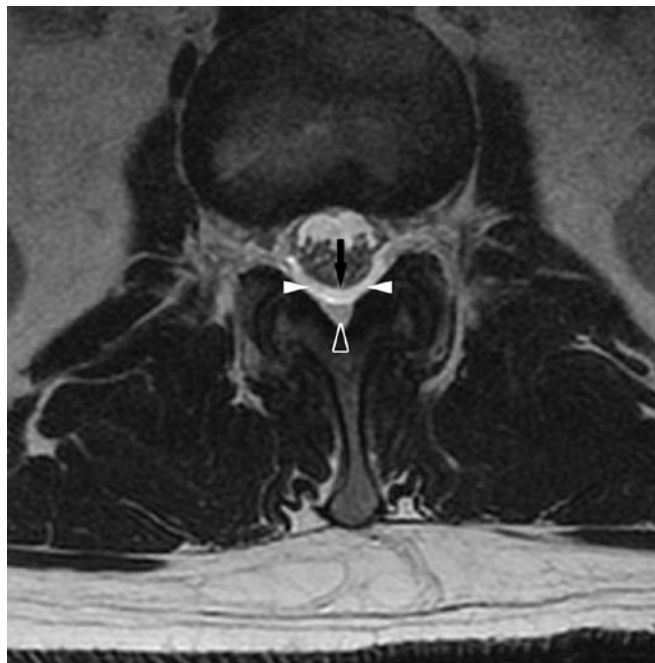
Axial T2-weighted image from lumbar spine MRI demonstrates an abnormal epidural fluid collection (white arrowheads) dorsal to the dura (black arrow) at L2-3. The fluid is slightly more hyperintense than the adjacent fat in the dorsal epidural space (open arrowhead). Because of the presence of this prominent epidural fluid collection, the decision was made to perform the epidural blood patch under CT-guidance.
